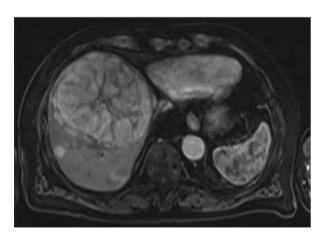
Axial MR images of three different focal liver lesions each exhibiting similar characteristics including enhancement during the arterial phase following intravenous gadolinium contrast administration and central 'scars'. These features are typical for focal nodular hyperplasia (FNH) but (a) is a hepatocellular carcinoma, (b) is a FNH lesion, and (c) is a fibrolamellar hepatocellular carcinoma.
